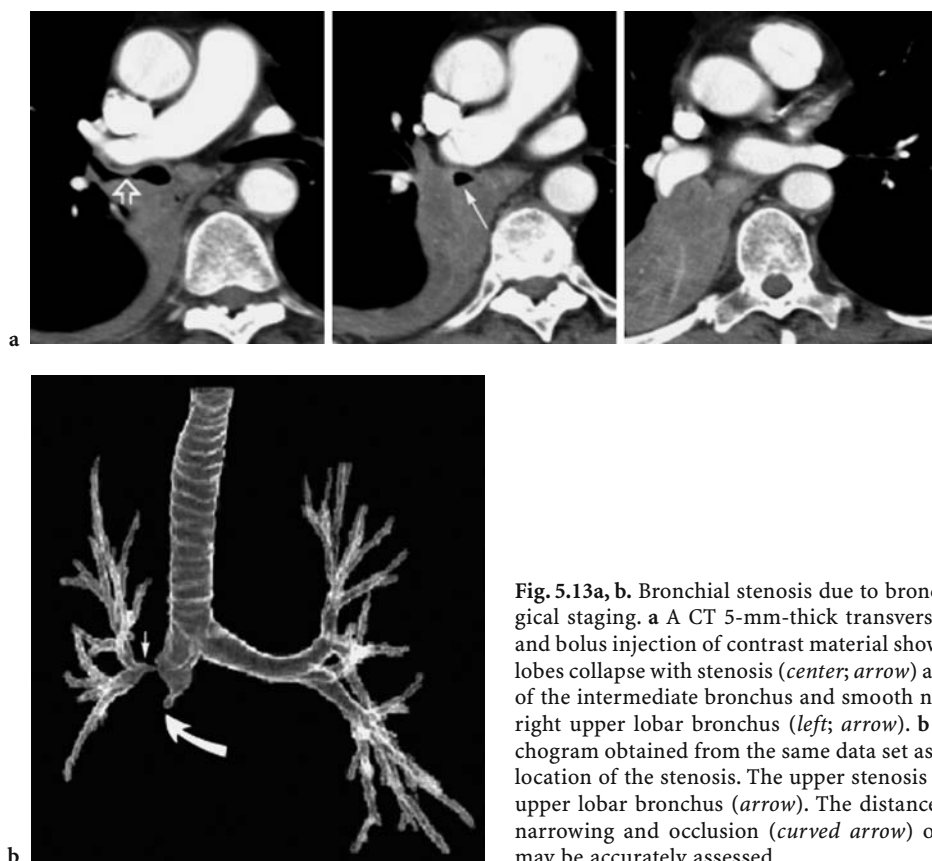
Bronchial stenosis due to bronchogenic carcinoma. Pre-surgical staging. a A CT 5-mm-thick transverse scan after MDCT scanning and bolus injection of contrast material showing a right middle and lower lobes collapse with stenosis (*center; arrow*) and complete occlusion (*right*) of the intermediate bronchus and smooth narrowing of the lumen of the right upper lobar bronchus (*left; arrow*). b Coronal view of a CT bronchogram obtained from the same data set assessing the shape, extent, and location of the stenosis. The upper stenosis is located at the origin of the upper lobar bronchus (*arrow*). The distance between the carina and the narrowing and occlusion (*curved arrow*) of the intermediate bronchus may be accurately assessed
